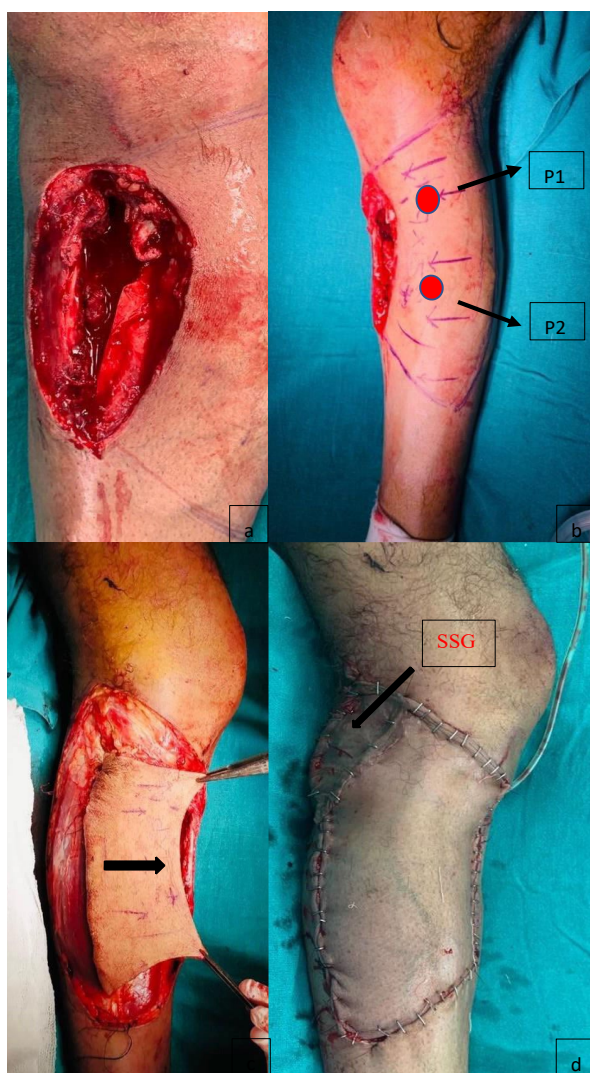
Clinical Case3. (a) Gustilo IIIa Compound fracture upper leg, wound measured 9 X 9 cm, (b) Two perforators P1 and P2 dopplered on medial aspect of wound and marked (arrowed), after debridement resultant defect measured 10 X 11 cm, Type IV Keystone flap chosen for reconstruction, (c) Flap incised circumferentially and advanced, (d) Upper one-third of donor area split skin grafted (SSG), immediate post-operative picture
